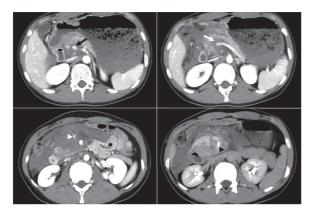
Abdominal computed tomography (CT) with contrast, axial view. (A) Decreased diameter of portal vein (PV) (black arrow) which was encased by surrounding hematoma. (B) A hematoma was over right upper quadrant of abdomen, with unapparent PV confluence of splenic vein (white arrow). (C) Contrast medium extravasation with massive hemoperitoneum (white arrow head). (D) Delayed phase, contrast medium extravasation (black arrow head) around PV. assessment sonography for trauma and detected fluid accumulation in the hepatorenal recess. Laboratory results showed high serum glutamic oxaloacetic transaminase and amylase levels. Computed tomography (CT) revealed a large hematoma with contrast extravasation at the mesenteric root with extensions around the main portal vein (PV) and right retroperitoneal space (Fig. 1). The superior mesenteric vein (SMV) and main PV were encased by the hematoma (Fig. 2).
